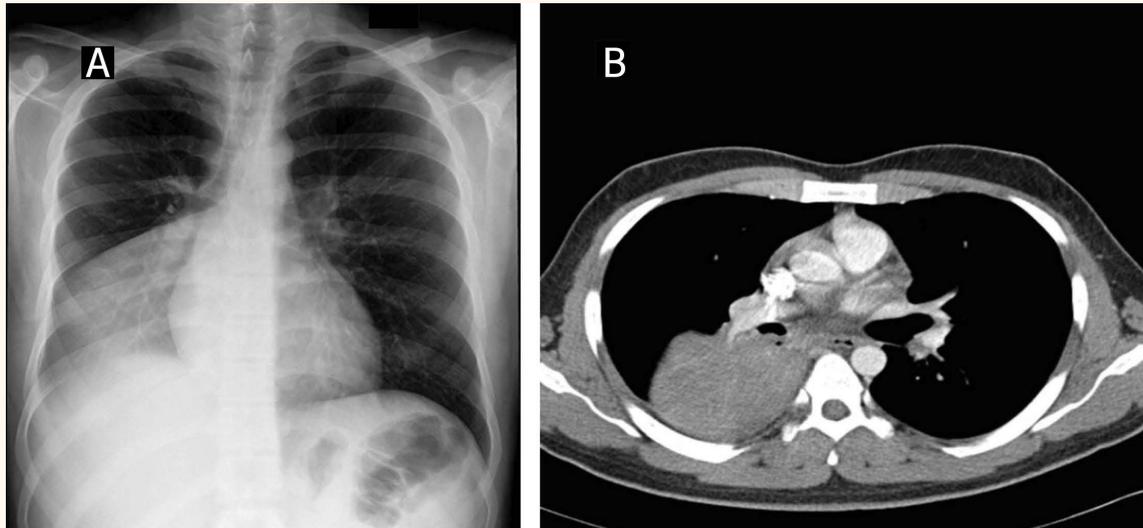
Chest imaging (A) X-ray and (B) computed tomography scan showing a right lower lobe collapse and endobronchial mass.
